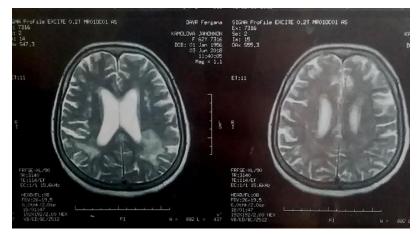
MRI signs of leukoareosis of the posterior horns of the lateral ventricles in both frontal-parietal regions.
